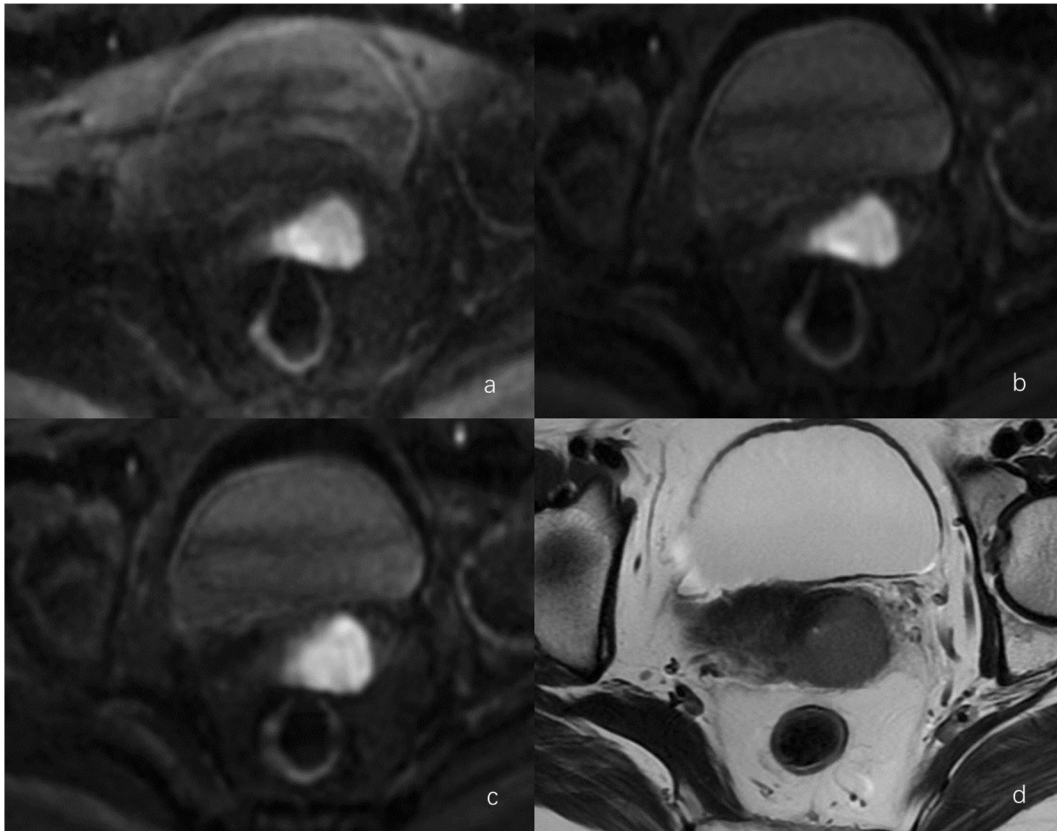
MRI images of a patient with cervical cancer. a) ssEPI DWI, b) MUSE DWI, c) RPG-MUSE DWI, d) T2-weighted. The RPG-MUSE DWI has minimal distortion of the cervical lesions and the rectum, and the anterior border of the rectum is shown more clearly.
